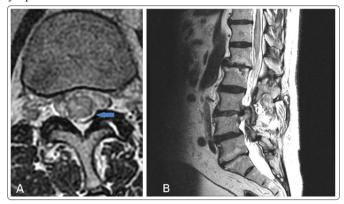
A) T2-weighted MRI axial image of the lumbar spine showing hyperintensity (blue arrow). B) Flow void pattern on sagittal image is seen along the L2 vertebral body.
